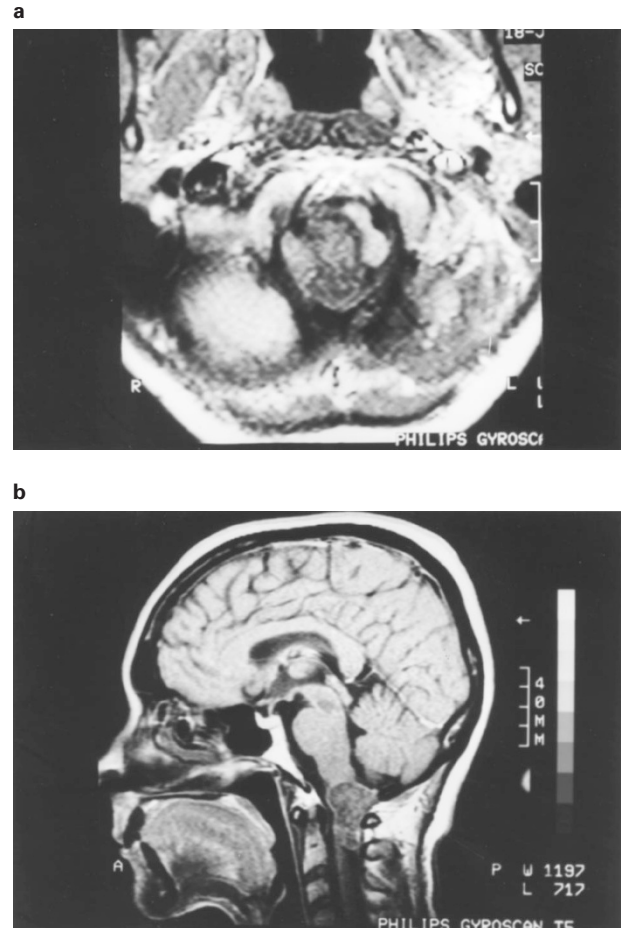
(A) MRI T₁ weighted: Axial view reveals tumor filling right side of foramen and markedly compressing and deforming brainstem to the left. (B) MRI T₁ sagittal view: Extension of tumor from body of C2 into posterior fossa
